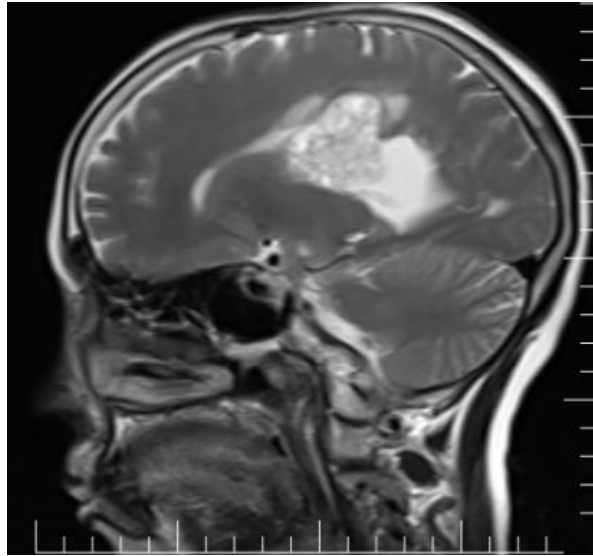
Brain MRI T2 Sagittal view showing hyperintense intraventricular mass lesion with mild
